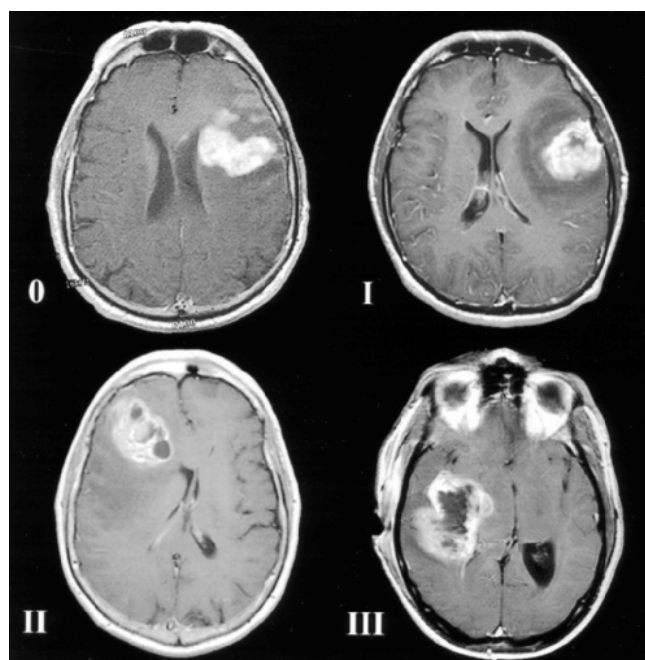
Grades of tumor necrosis adapted from Hammoud, et al. are demonstrated on MR images. The amount of tumor necrosis, which appears as an area of decreased signal intensity on T₁-weighted images, was divided into four grades as follows: Grade 0, no necrosis apparent on the MR image; Grade I, amount of necrosis less than 25% of the tumor volume; Grade II, amount of necrosis 25 to 50% of the tumor volume; and Grade III, amount of necrosis greater than 50% of the tumor volume.
